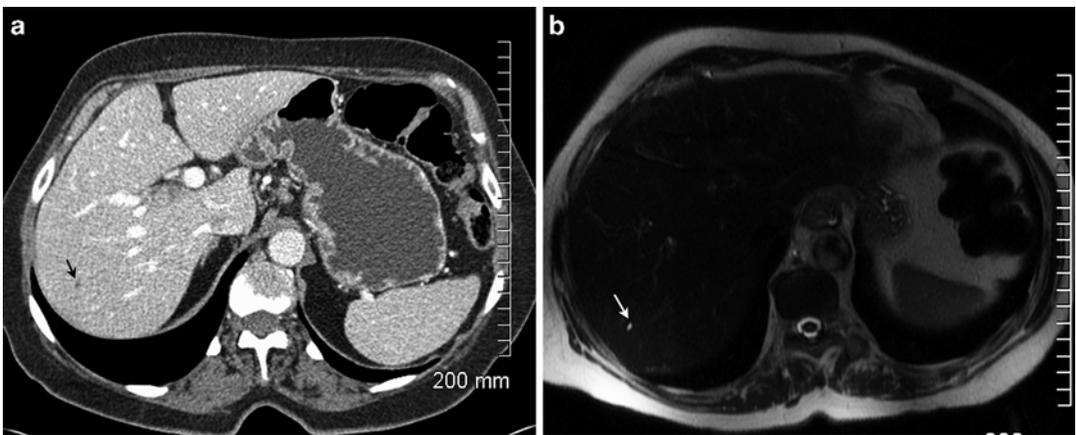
A tiny low attenuation lesion (arrow) is seen on CT (a). On T2 weighted MR (b), the lesion is well circumscribed and high in signal intensity consistent with a cyst
